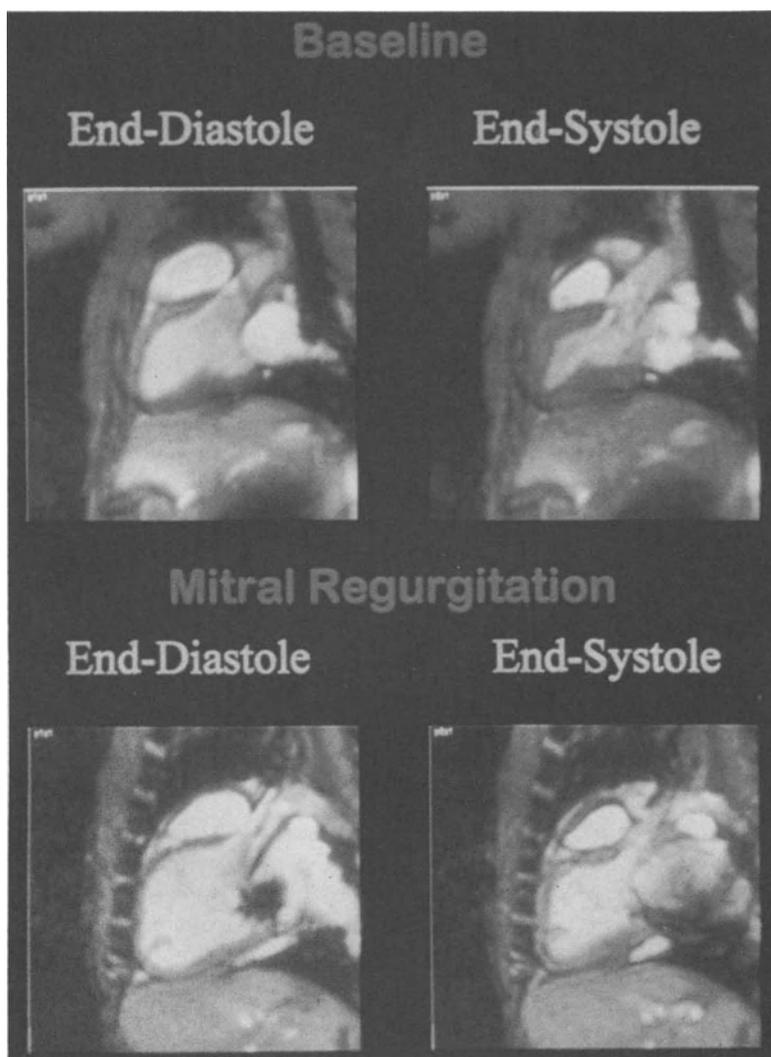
Long axis and short axis end-diastolic and end-systolic magnetic resonance images of the heart at baseline and 5 months after induction of mitral regurgitation, demonstrating the increase in end-diastolic volume and the decrease in wall thickness that occurs as a result of a decrease in the LV mass volume ratio. (Reproduced with permission from Le Jacq Communications, Inc.).
